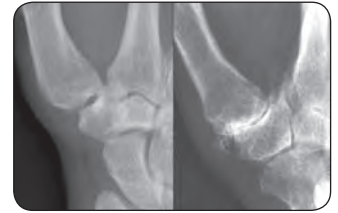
X-ray of first carpometacarpal joint: normal image (left) and osteoarthritis (right) with joint space narrowing and subchondral sclerosis
